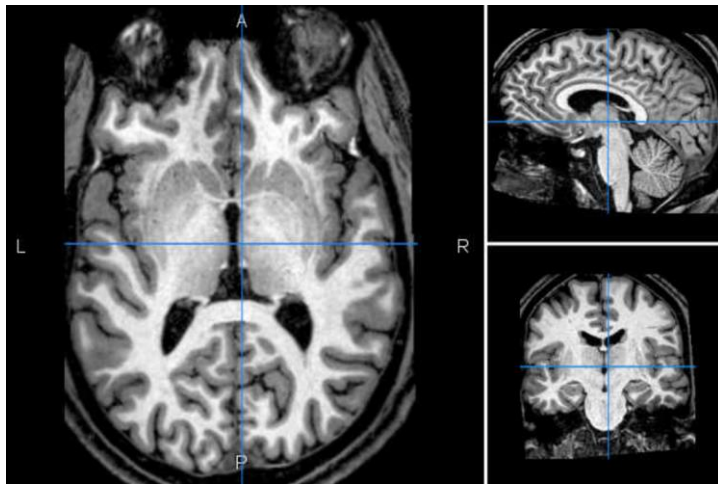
T1-weighted MRI scan [42]
